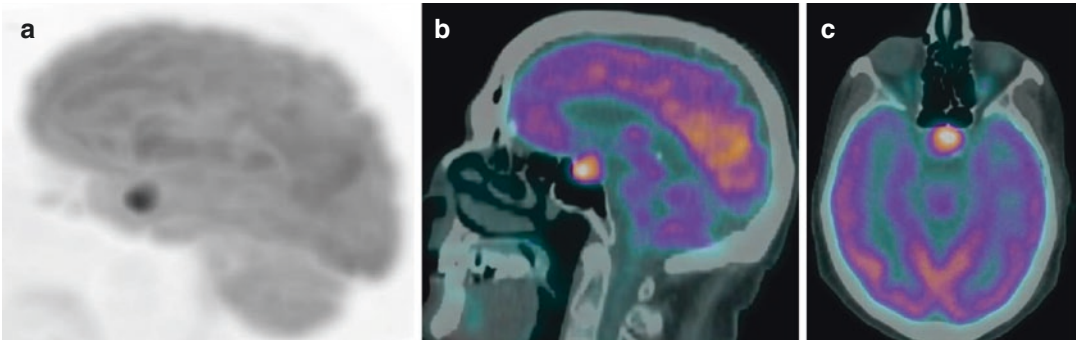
^{18}F -FDG uptake can be incidentally detected in association with pituitary adenoma, as evident in PET 3D maximum intensity projection of the brain (a) and relative axial (b) and sagittal (c) PET/CT views
